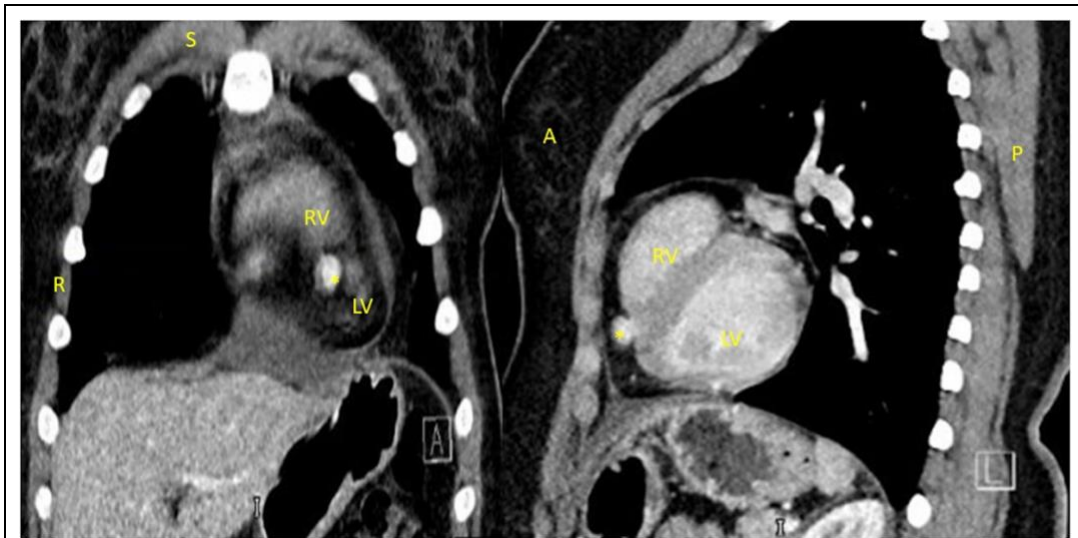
Coronal CT slice and sagittal CT slice. A-anterior, LV-left ventricle, P-posterior, R-right of patient, RV-right ventricle, S-superior, *-pseudoaneurysm.
